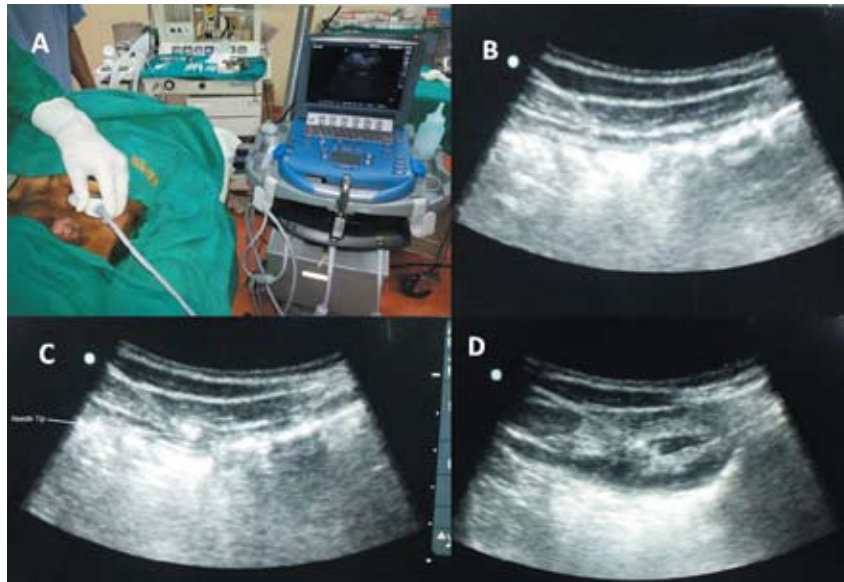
Manoeuvring of ultrasound probe for identification of transverses abdominis plane
